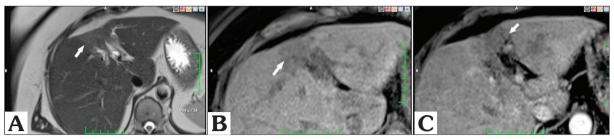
Posttreatment MRI scan. (A) The axial T2-weighted image without fat suppression shows a decreased irregular hyperintense signal (arrow). (B) The axial T1-weighted image shows a decreased irregular hypointense signal (arrow). (C) The contrast-enhanced axial T1-weighted image shows hypovascularity and disappearance of peripheral enhancement (arrow).
